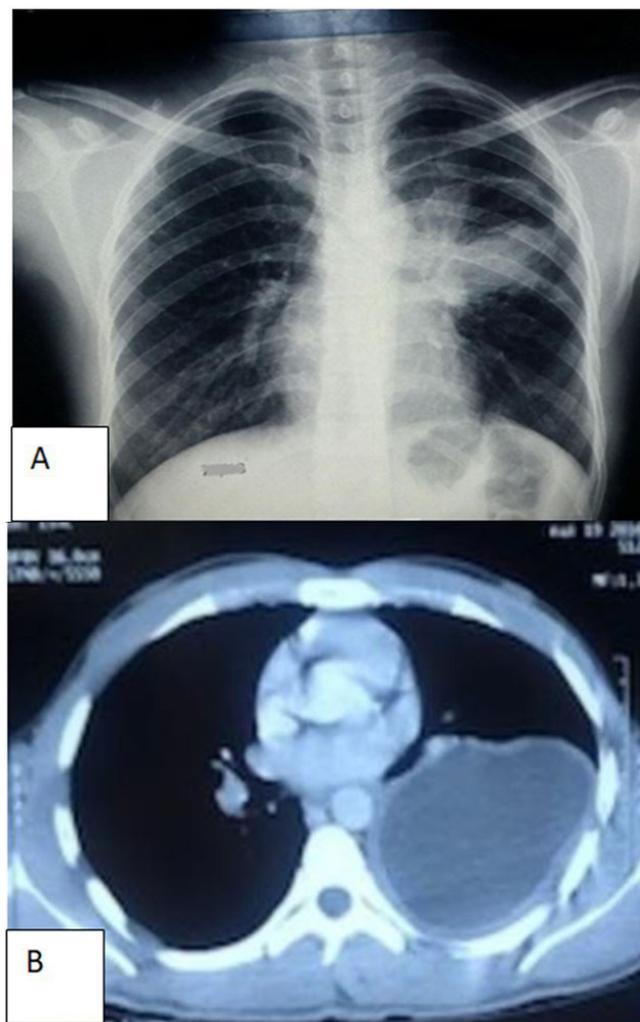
A: Front chest radiograph showing ruptured hydatid cyst in the bronchi of the left fissure B: Chest CT showing a hydatid cyst of the left fissure
